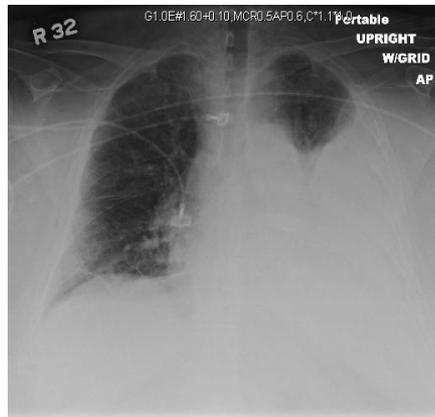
Chest x-ray with a large left-sided pleural effusion.
